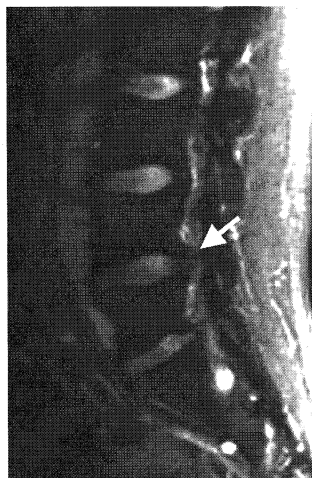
Sagittal T2-weighted magnetic resonance image (MRI) 5 mm left side from the mid-line showing the L4-L5 herniation extruded toward the cephalad direction (arrow).
